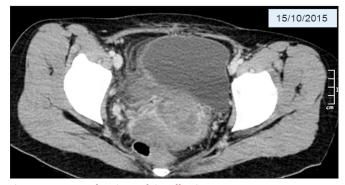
CT Scan showing pelvic collection in broad ligament on right side
